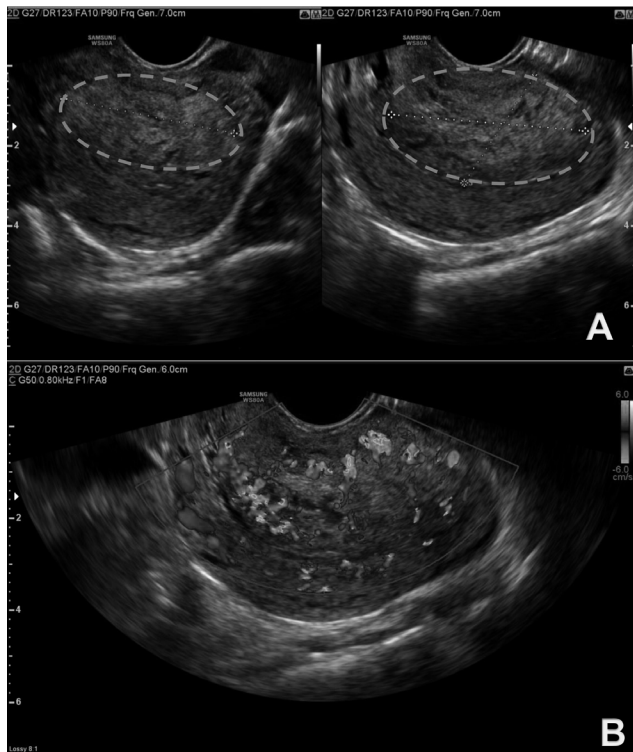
Transvaginal ultrasound of first molar pregnancy (2019)
